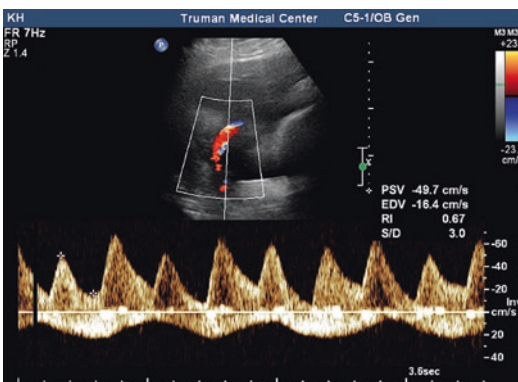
Fetal breathing and umbilical arterial Doppler waveforms. Observe the dynamic variations in the arterial and venous Doppler tracings
